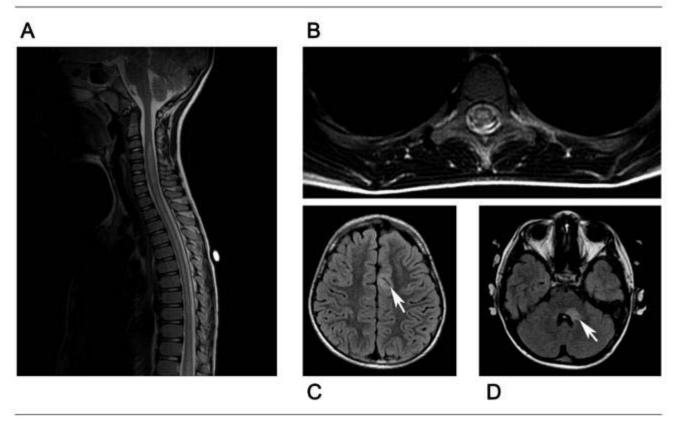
An 8-year-old boy with acute transverse myelitis without encephalopathy or supraspinal signs. A, Sagittal T2 image of the spine showing involvement of the entire spinal cord with cord expansion in the cervical region. B, Axial T2 spinal image showing predominantly gray matter involvement. C, Axial FLAIR image of the brain showing high signal in the left frontal cortical gray matter (arrow). D, Axial FLAIR image of the brain showing high signal in the left superior cerebellar peduncle (arrow). FLAIR = fluid-attenuated inversion recovery.
